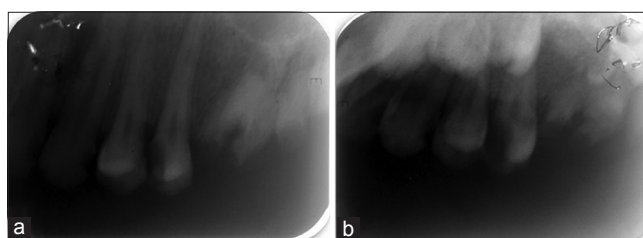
(a) Intraoral periapical radiograph of the maxillary first molar root piece. (b) Extraoral periapical radiograph of the maxillary first molar root piece
